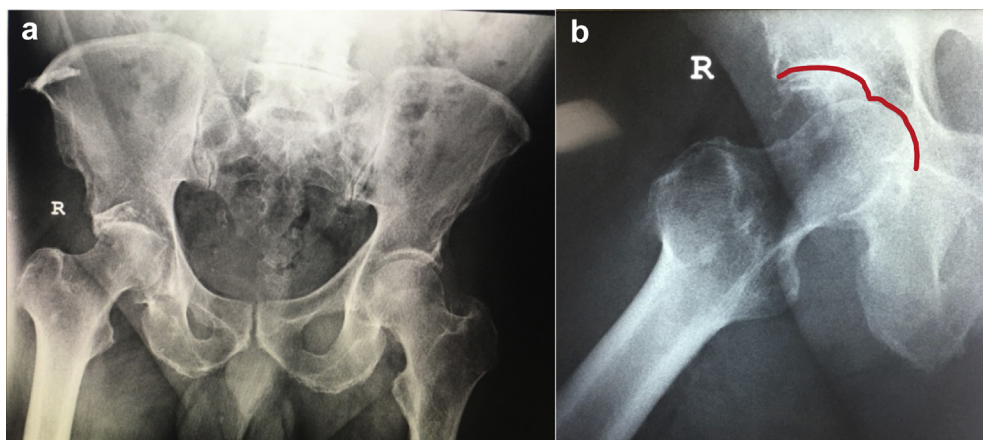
Initial anteroposterior radiograph (a) and lateral radiograph (b) in accident and emergency demonstrating the Gull-wing sign (red) pathognomic of a posterior wall fracture and subluxation of the femoral head.
